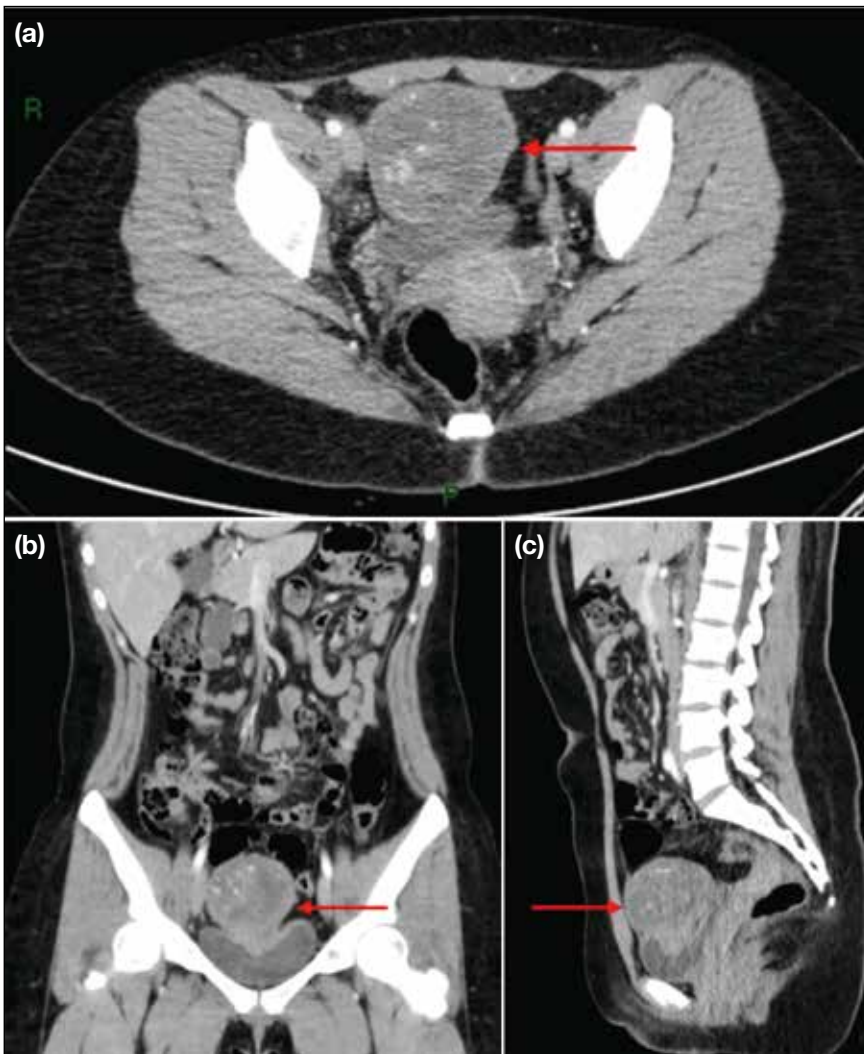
Contrast-enhanced multi-slice computed tomography urography in (a) axial, (b) coronal, and (c) sagittal views. A well-defined lobulated non-enhancing mass with intrinsic punctate calcifications (arrows) is seen at the supravescical region with involvement of the bladder dome. The mass is slightly less attenuating than the adjacent soft tissue, a finding suggestive of a mucus-filled structure.
